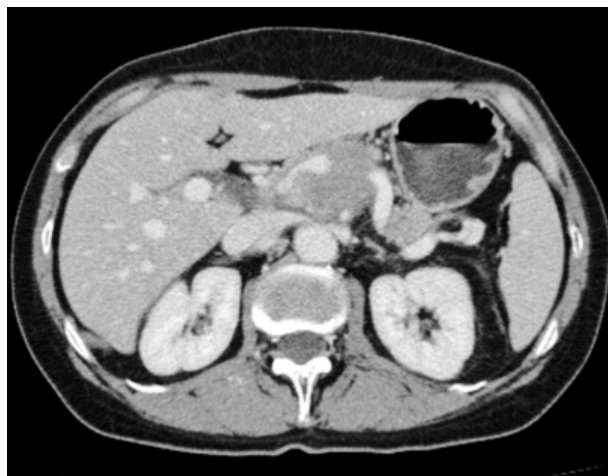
CT (26/12/17). Abdominal CT findings: a 4.5-cm hypervascular mass with a rough border can be observed in the body of the pancreas. The mass semicircularly covers the celiac trunk, the superior mesenteric artery, common hepatic artery
